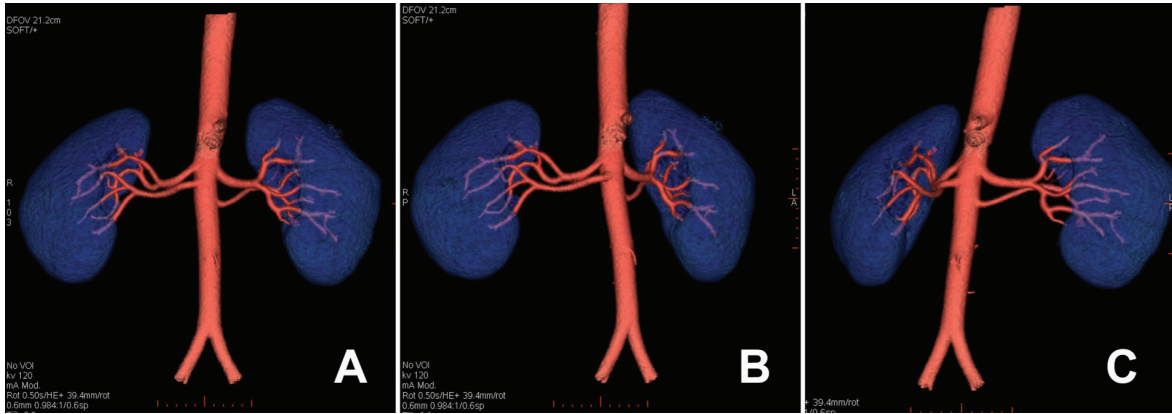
34-year-old female renal donor with supernumerary renal arteries. A-C) Rotating 3-D volume-rendered CTA images demonstrate two right renal arteries and two left renal arteries
